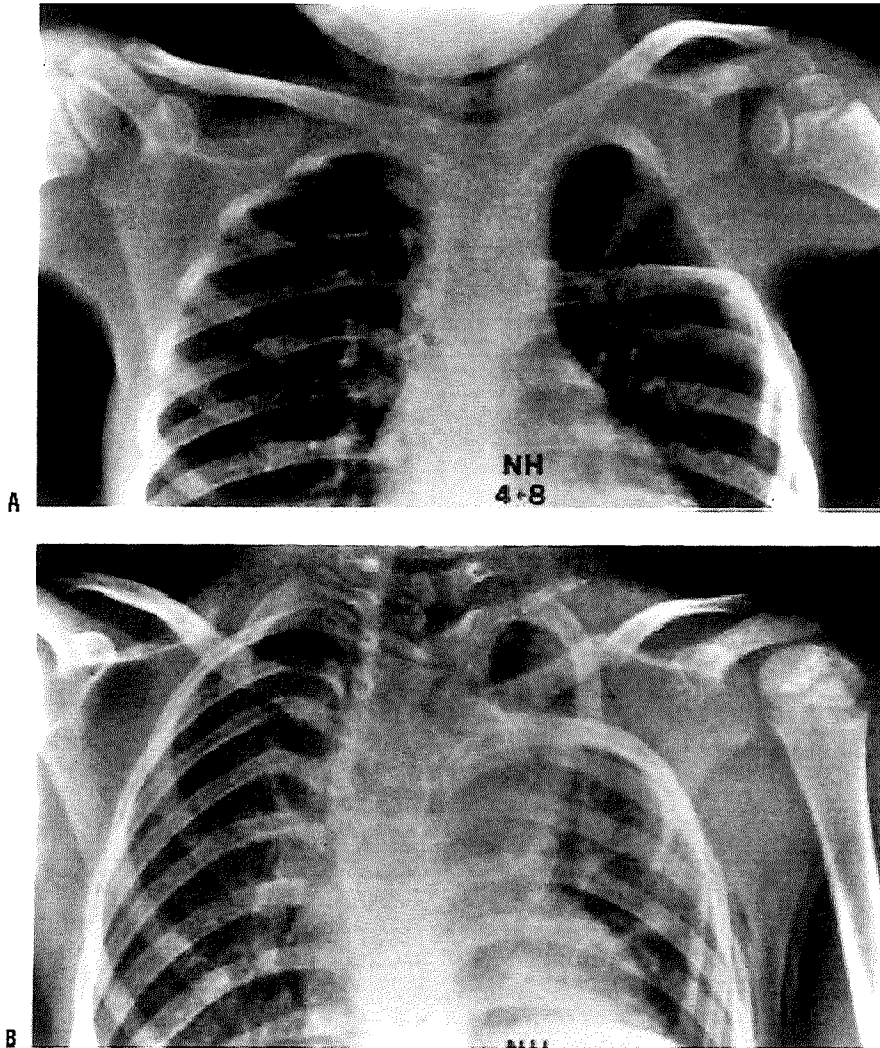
NH is a 4-year, 8-month-old girl who presented with a high left shoulder and restricted motion, which the parents had observed. They had consulted an orthopaedic surgeon 2 years previously and were told that treatment would not be advisable as she would just be trading a slightly high shoulder for a very large scar. However, the parents were convinced that the deformity was becoming worse. A: A preoperative radiograph shows many of the skeletal anomalies seen in association with the congenital elevation of the scapula. The most obvious is that the scapula is high, but it is also smaller than the opposite scapula. There is a defect in the chest wall, with missing and deformed ribs and mild scoliosis with a vertebral anomaly. B: Postoperatively, the spine of the left scapula is on the same level as in the normal scapula. Its smaller size is obvious and demonstrates that the affected scapula should not be brought so far inferior that the inferior angle is on the same level as the normal scapula.
